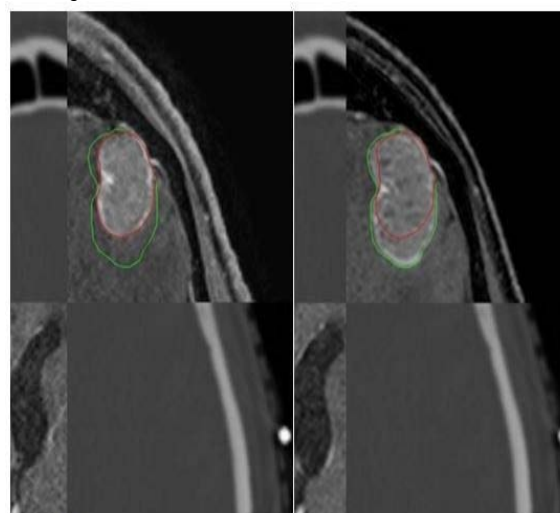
Delineations on diagnostic (left) and planning MRI (right), both registered on planning CT.
